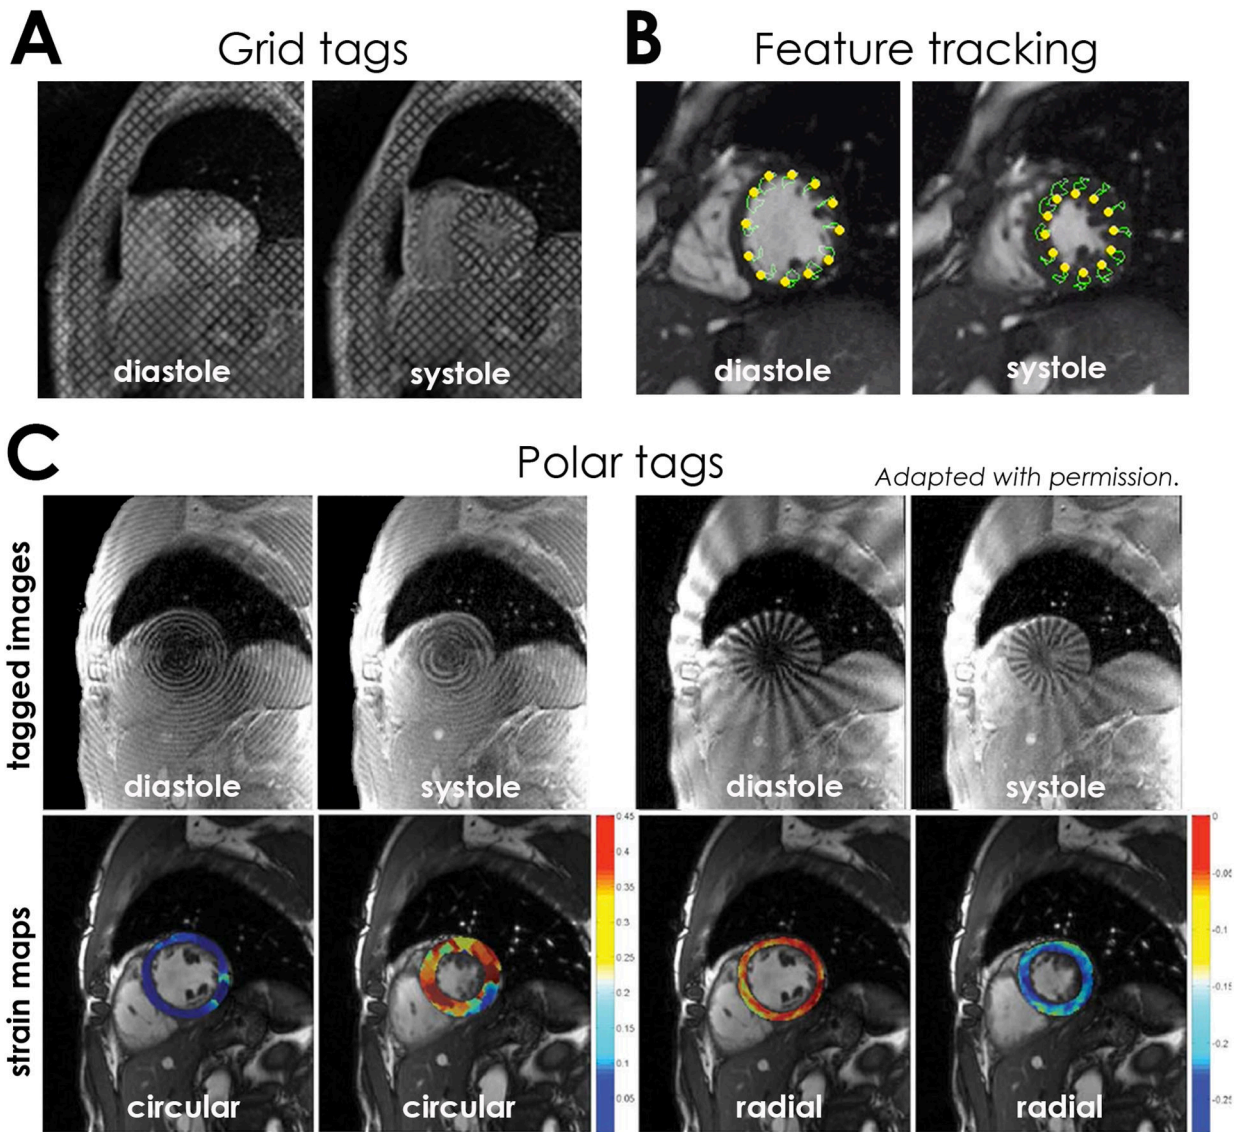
Myocardial mechanics can be quantified using rectilinear grid tags (A), feature tracking (B), or polar tags (C) in the circular and radial directions. Global and regional strain curves can be used to derive longitudinal, circumferential, and radial strain and strain rate. Rotational mechanics (torsion) is quantified using short-axis images. Panel C is adapted from Nasiraei-Moghaddam A, Finn JP. Tagging of cardiac magnetic resonance images in the polar coordinate system: physical principles and practical implementation; with permission. *Magn Reson Med.* 2014;71:1750–9. (Figure 6 in original)
